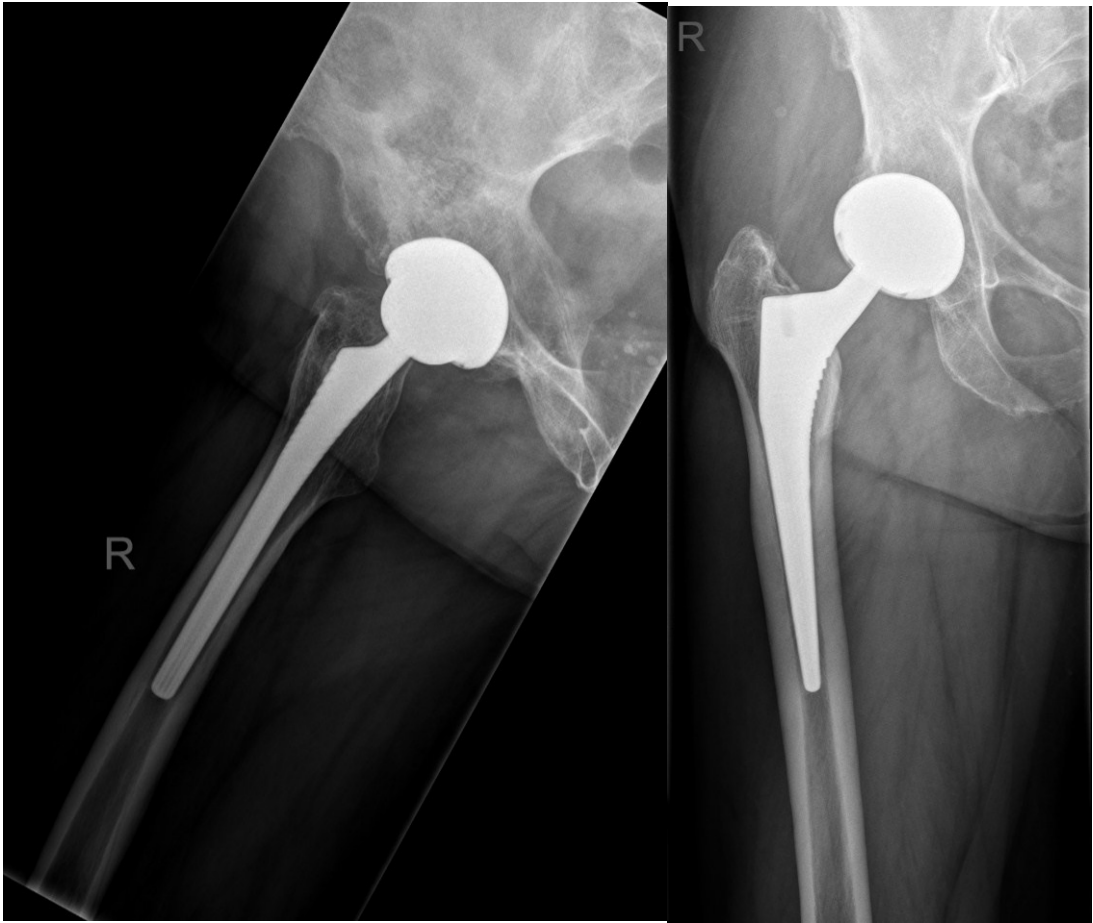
X-rays in lateral (left) and a.p. (right) view of the right hip joint of a 71-year-old male patient showing a Total Hip Arthroplasty (THA).
